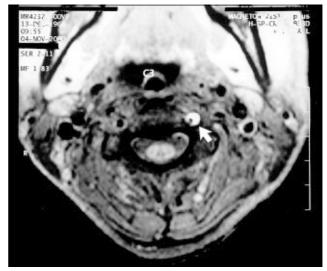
Spin-echo T1-weighted fat suppression axial magnetic resonance imaging at the C3 level, showing a haematoma in the wall of the left vertebral artery and narrowing of the lumen (white arrow)
